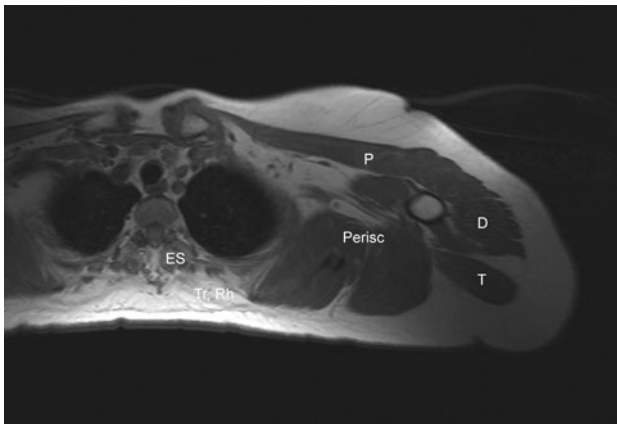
MRI scan T1 weighted, demonstrating fat replacement of thoracic paravertebral muscles (pat. 6). *ES* erector spinae muscles, *D* deltoid muscle, *P* pectoralis muscle, *Perisc* periscapular muscles, *Rh* rhomboid muscle, *T* trapezius muscle
